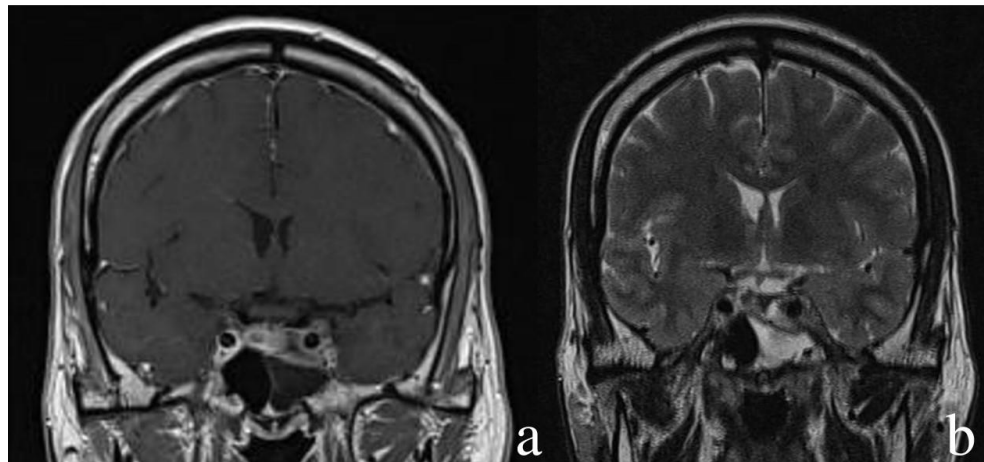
a- coronal T1 + contrast MRI showing a pituitary adenoma invading the left cavernous sinus with a heterogeneous enhancement- coronal T2 showing a CSF collection in the left sphenoid sinus.
